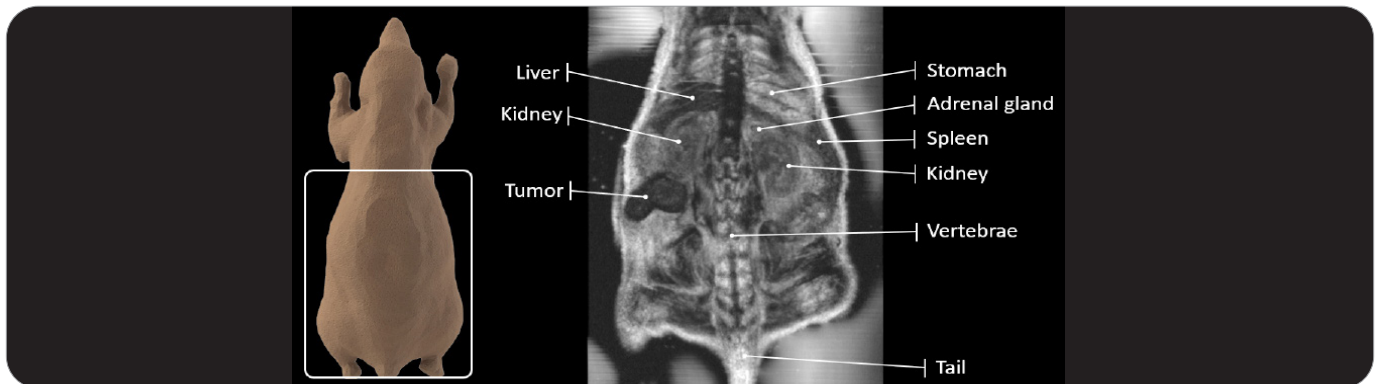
Example of Vega's widefield imaging capability showing detailed anatomy. Coronal plane image reconstructed from widefield 3D ultrasound data.
